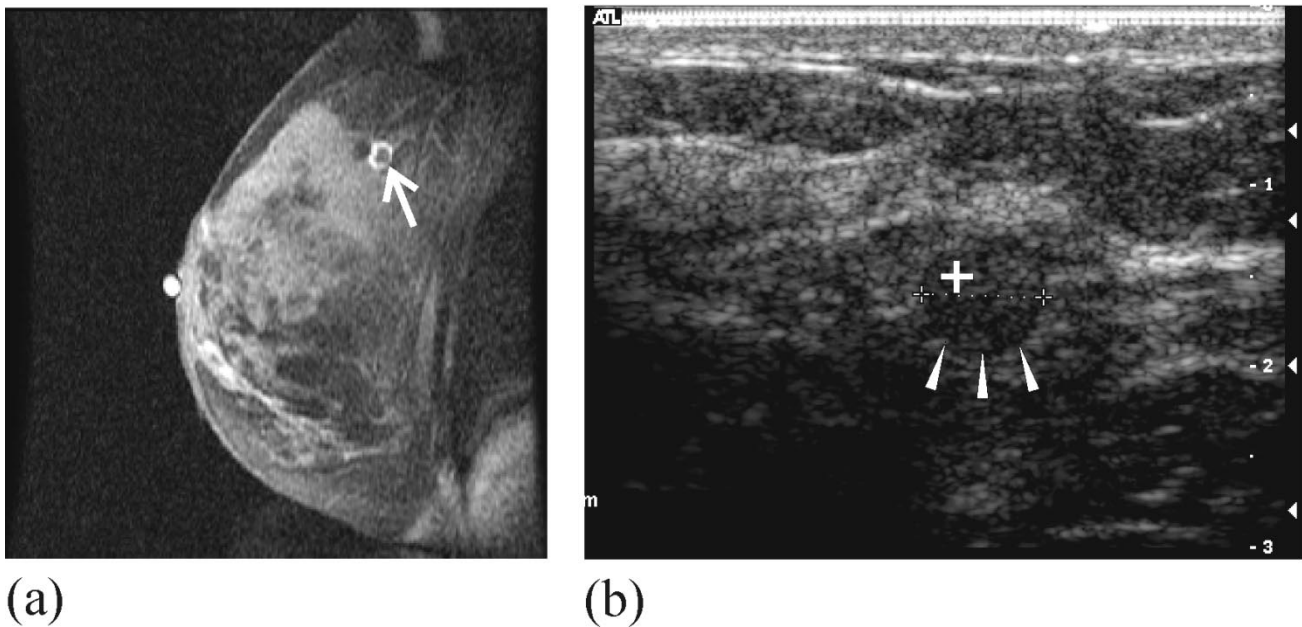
Clinical Application of MR-US co-registration (a) Rim-enhanced lesion detected with Contrast-enhanced MRI (arrow). (b) Co-registered US image depicting 7-mm lesion at a position 3.0 mm from the predicted MRI position (crosshair). Registration error was determined to be (X , Y , and Z) 2.0, 1.0, and 2.0 mm. This lesion was surgically excised and diagnosed to be an invasive ductal carcinoma.
